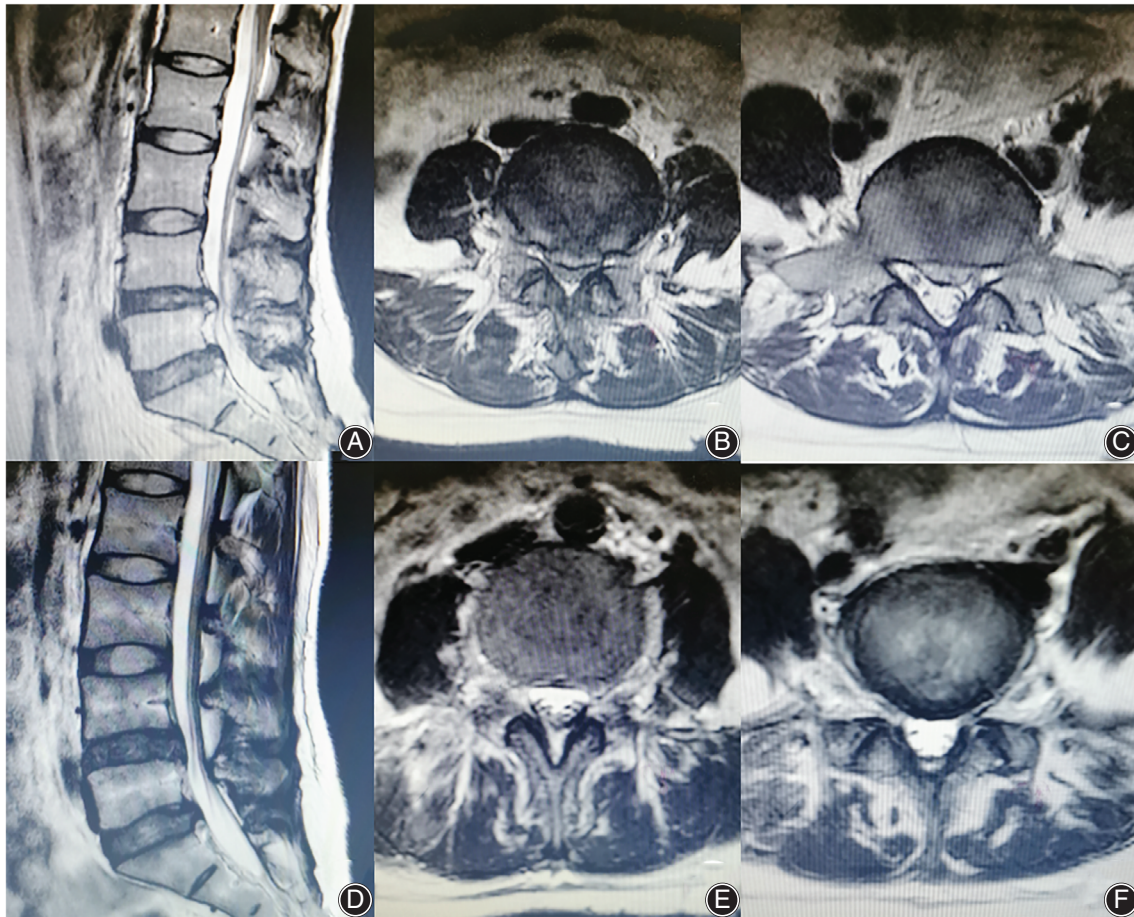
A 29-year-old female patient. (A–C) The preoperative MRI revealed L4/5 and L5/S1 two-level disc herniation. (D–F) Postoperative MRI (Day 3) showed that the compression was released.
